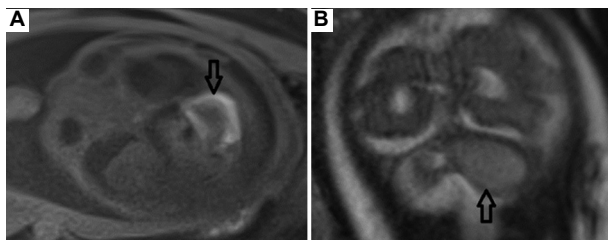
MRI characterization of subacute cerebellar hemorrhage is more convenient. (A) Axial T1 and (B) coronal TRUFI images show a right cerebellar hematoma (black open arrow) involving the vermis.
